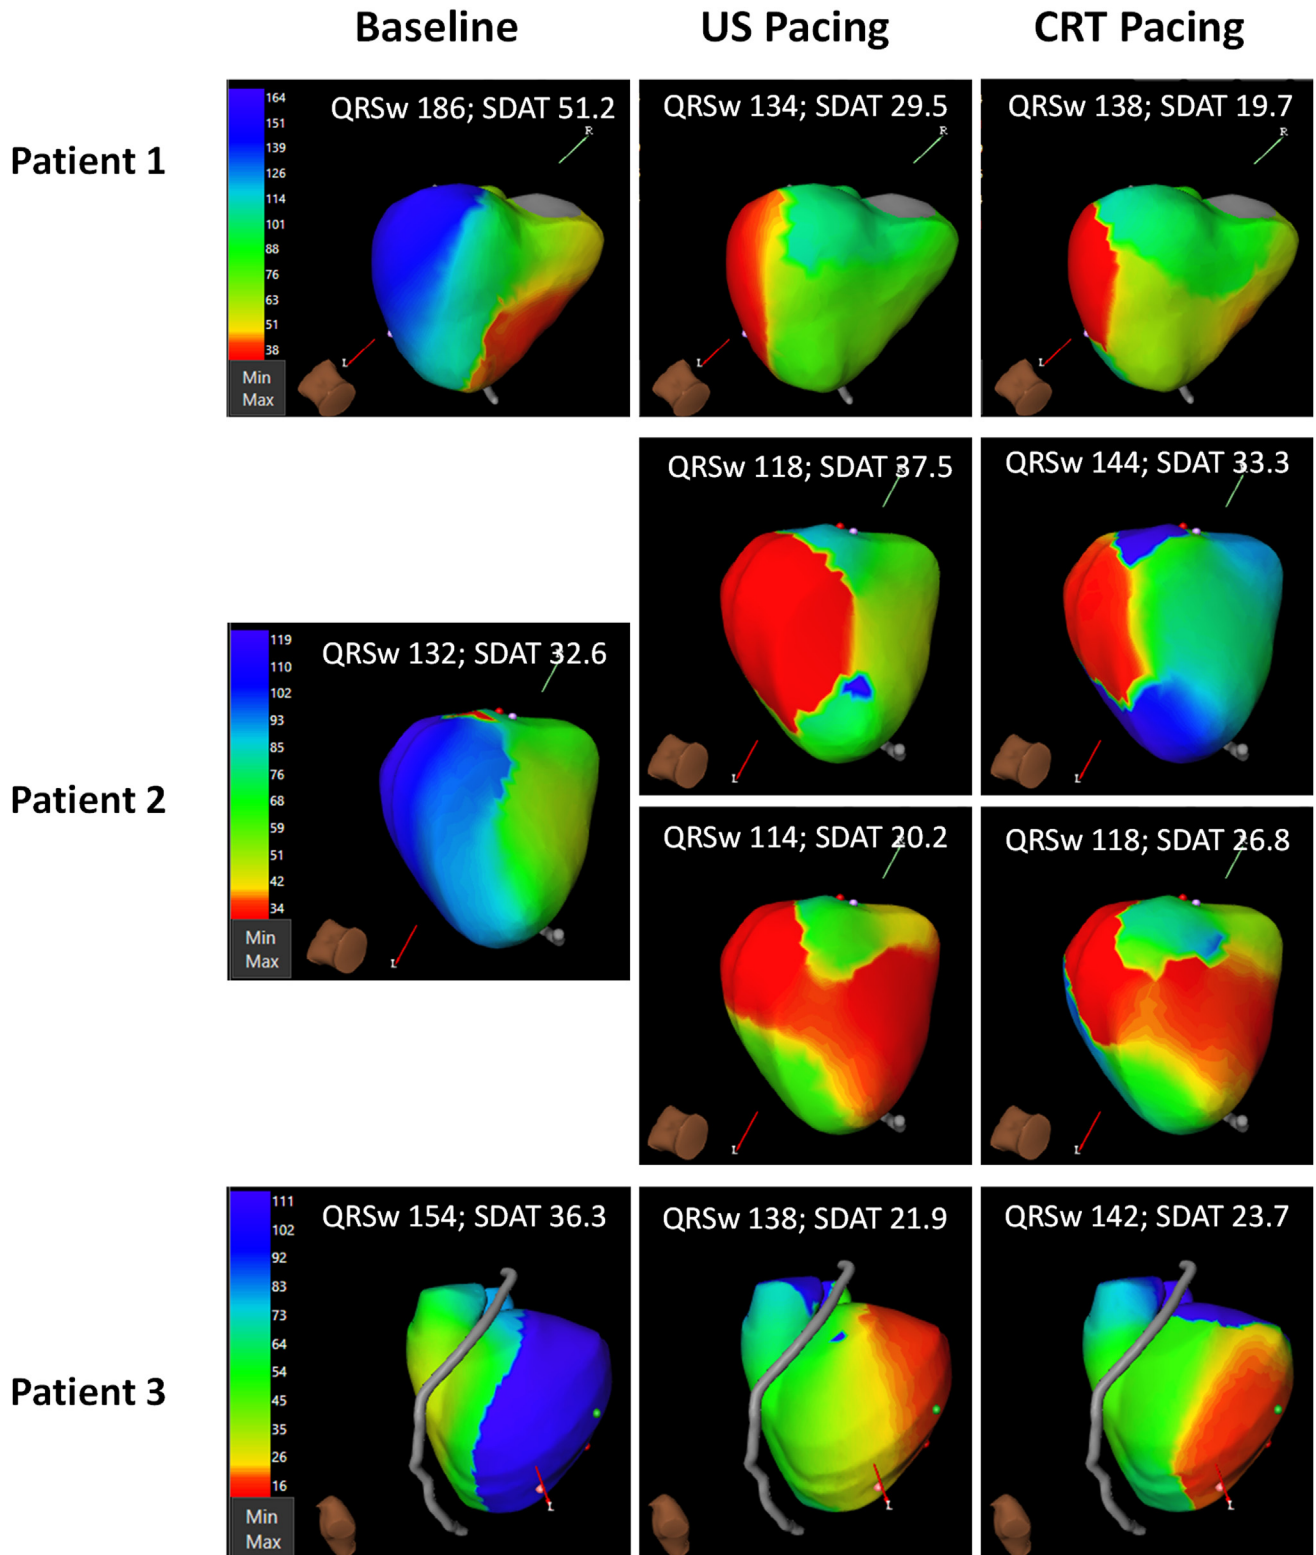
CardioInsight maps for cardiac resynchronization therapy (CRT) pacing and ultrasound (US) pacing. CardioInsight activation maps for 3 patients are shown. Left: Intrinsic depolarization. Middle: Ultrasound paced beat. Right: CRT pacing. For each patient, the activation time scales are equivalent. QRSw = QRS width; SDAT = standard deviation of activation time.
